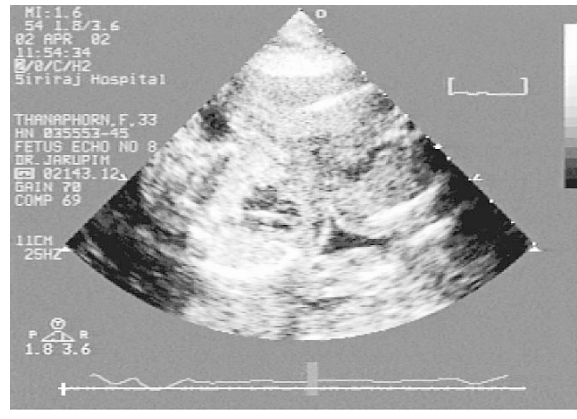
Fetal echocardiogram of conjoin twin with normal cardiovascular systems
